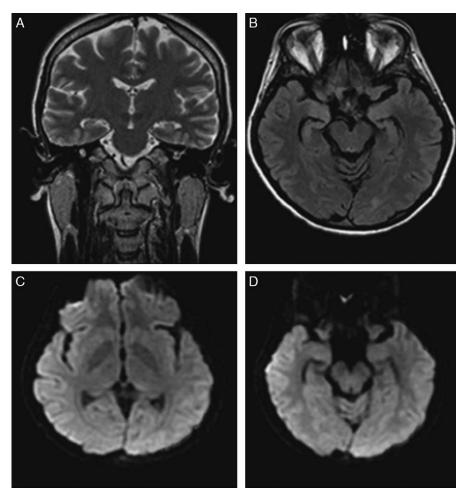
A and B, Axial fluid attenuated inversion recovery (FLAIR) images; C and D, axial diffusion weighted images (DWI). FLAIR and T2w images show atrophic and gliotic changes of temporal uncus, hippocampal formation, insular subcortical white matter, and pulvinar, characterized by faint hyperintensity on T2wi. On DWI all signal intensity alterations disappeared.
